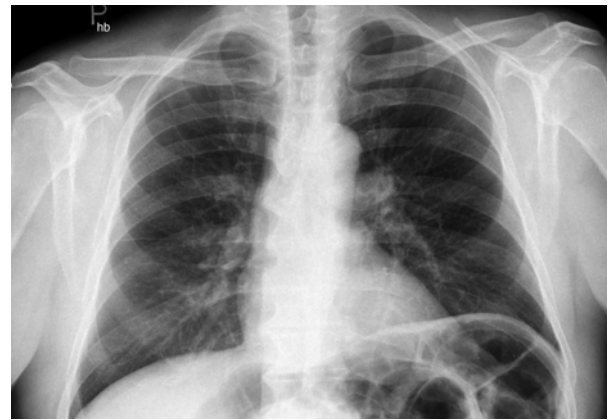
Chest X-ray 35 hours after initial examination — complete regression of opacities
